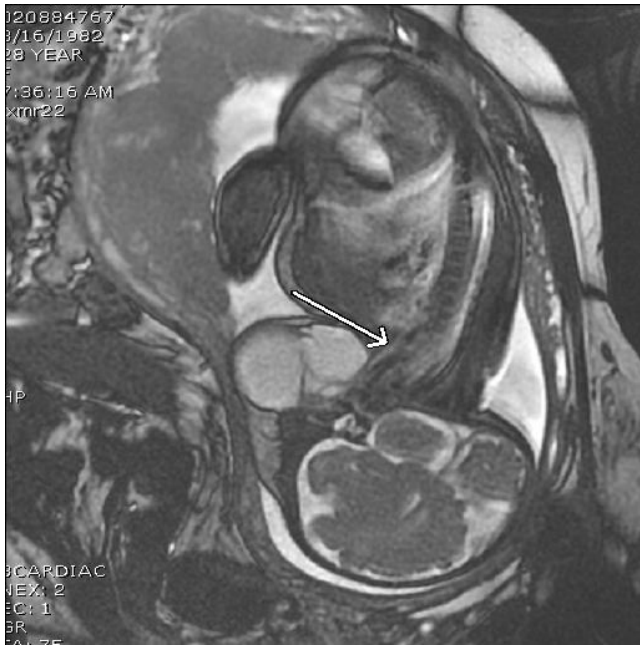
Prenatal imaging of fetus by MRI.
